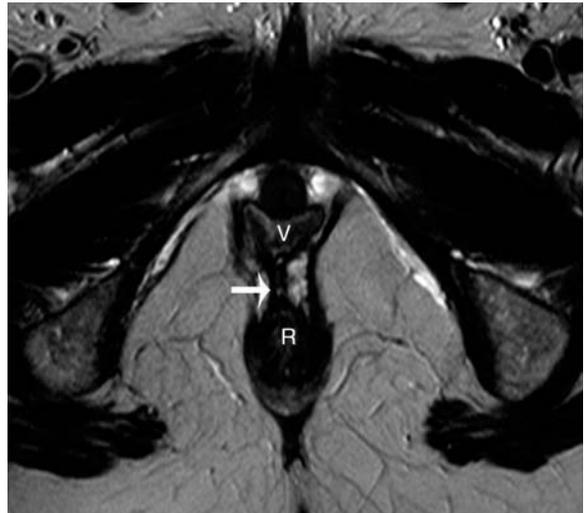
Chronic rectovaginal fistula in a 45-year-old female. Axial T2-weighted image shows a low T2 signal intensity track (arrow) between the rectum (R) and vagina (V) due to fibrosis.
